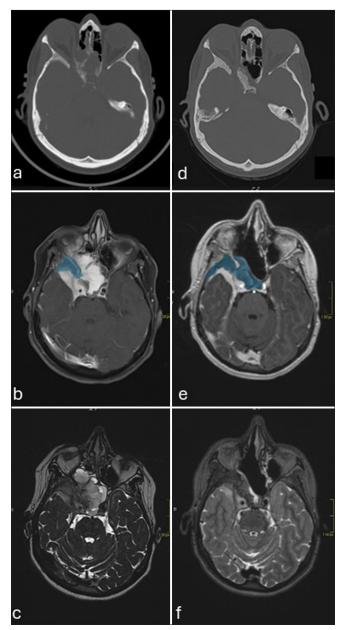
Radiological evaluation of the intra-osseous meningioma progression. (a and b) Bone computed tomography (CT) scan at presentation and 3 months after the first surgery. (c and d) T1 post gadolinium magnetic resonance imaging (MRI) at presentation and 3 months after the first surgery. (e and f) T2 MRI at presentation and 3 months after the first surgery. The blue areas correspond to the volumetry of the osseous part of the lesion before the first surgery (a) and 3 months after this treatment and cessation of Nomegestrol Acetate therapy (c). We realized the volumetry analysis by comparison between the CT scan at the MRI sequences. We demonstrated the bony progression with a growth from 8.88 cm<sup>3</sup> to 17.53 cm<sup>3</sup>.
